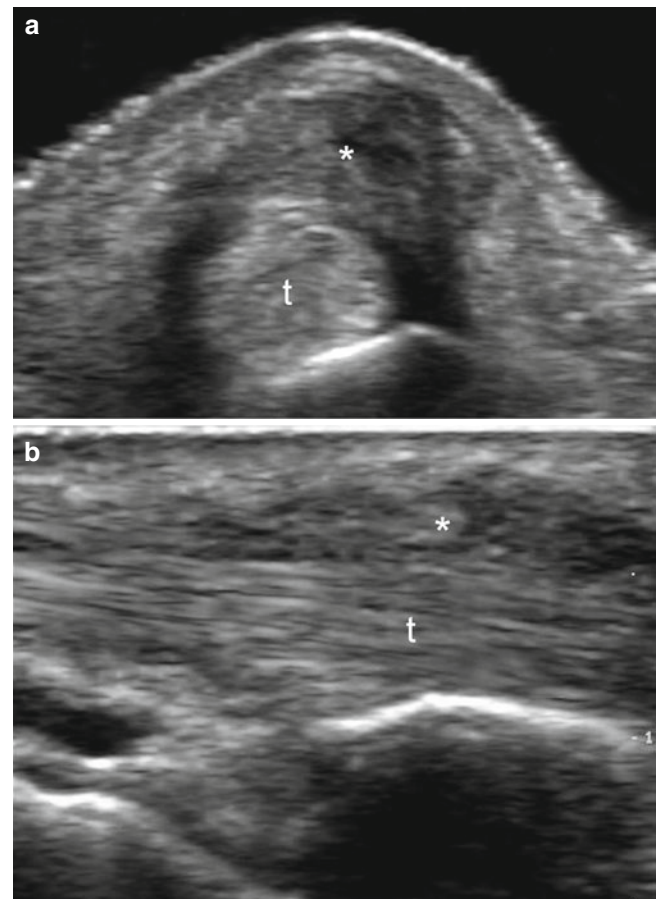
(a–c) Quervain's tenosynovitis. (a, b) Grey scale ultrasound images (a transverse view; b longitudinal view; left wrist) show prominent thickening of the synovial sheath (*) of the abductor pollicis longus tendon (first compartment of the wrist). The tendon (*t*) is also enlarged. (c) 3D reconstruction highlights the thickening of the tendon and sheath. *Abbreviation:* t tendon
